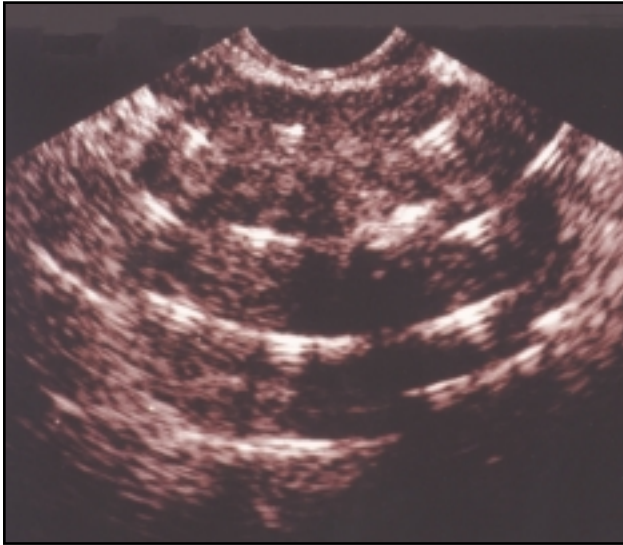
Needle insertion under ultrasound guidance, coronal view.
